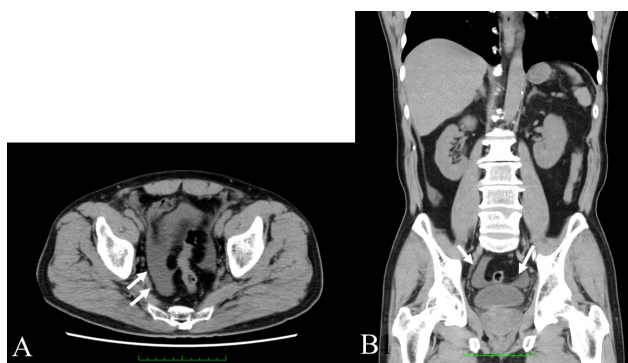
Pre-operative CT findings: Peritoneal and omental lesions are difficult to detect on imaging studies. Small amounts of ascites (arrows) are observed in the pelvic cavity. (A) Axial (B) coronal views.
